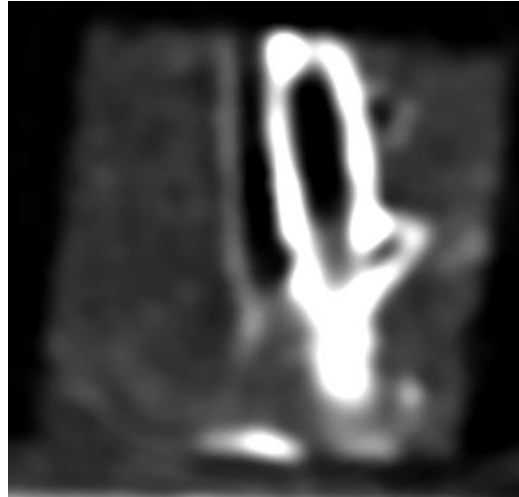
Cube B8L7C2R4 imaged in CT. Each of the cubes was imaged in CT to acquire the highest resolution possible with the SOMATOM CT system. Note the brightness of the wall surrounding the airway.
